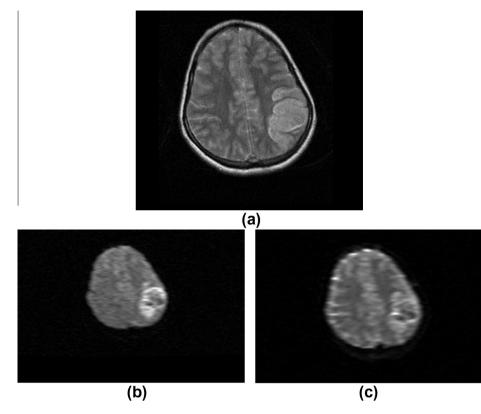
(a) T2 WI showing area of high signal intensity seen in the left occipital region. (b) Coronal FLAIR showing area of high signal intensity in the left occipital region. (c) DWI showing area of restricted diffusion (high SI) in the left occipital region. (d) Left occipital low SI in ADC map denoting infarction.
